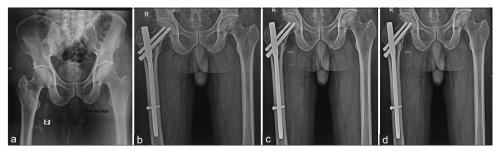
Case 2: 61-year-old male, right basicervical neck of femur – proximal femoral nail (a) pre-operative X-ray (b) immediate post-operative X-ray (c) 6-month follow-up (d) 12-month follow-up
